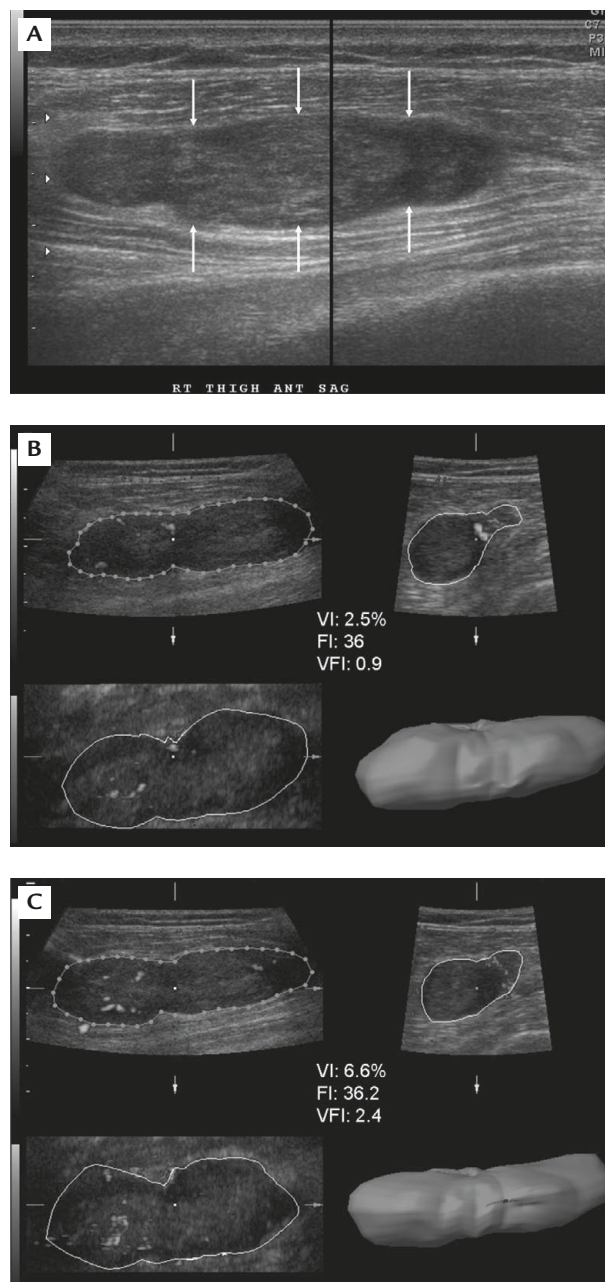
A 63-year-old male patient with the complaint of a right thigh mass. (A) 3D power Doppler ultrasonography shows an ovoid-shaped hypoechoic nodule with mild vascularity (VI, 2.5%; FI, 36; VFI, 0.9). (B) 3D power Doppler ultrasonography shows an ovoid-shaped hypoechoic nodule with mild vascularity (VI, 2.5%; FI, 36; VFI, 0.9). (C) After contrast injection, 3D power Doppler ultrasonography shows relatively increased vascularity (VI, 6.6%; FI, 36.2; VFI, 2.4). This tumor was determined to be a schwannoma.
